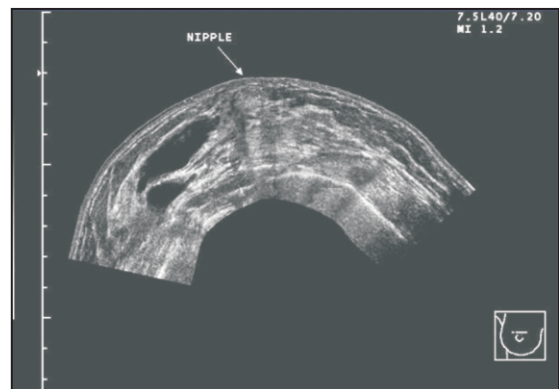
Ultrasound shows the relationship of the dominant cyst to other masses in this patient.
